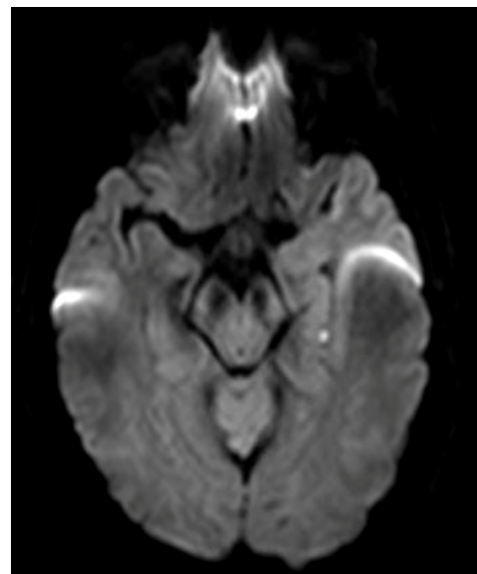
Transient Global Amnesia MRI.
